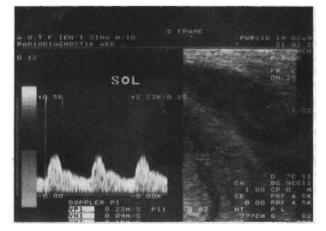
Doppler sonogram of a patient with penile arterial inssufficiency. Longitudinal color Doppler sonogram shows left cavernosal artery with angle-corrected cursor placement. Spectral waveform 5 min after papaverine injection shows peak-systolic velocity less than 25 cm/sec with continuous diastolic flow.
